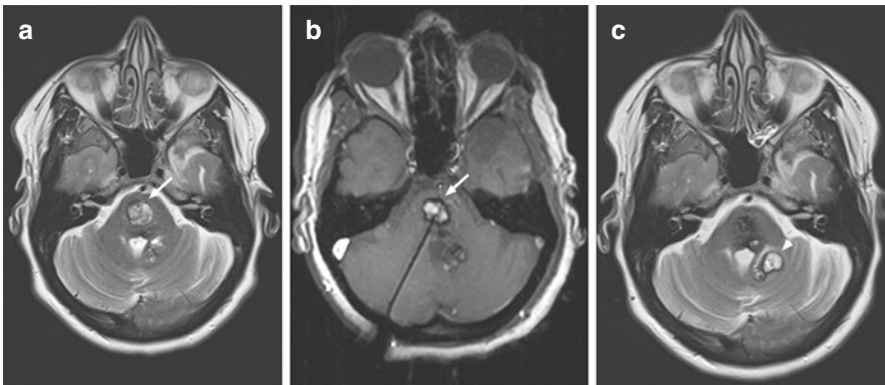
Case 1—LITT treatment of a pontine CM. (a) Preoperative axial T2-weighted MR imaging demonstrates a pontine cavernous malformation (arrow) with heterogenous hyper- and hypointense features. (b) Perioperative axial T1-weighted, contrast-enhanced MR image shows the right cerebellar approach for LITT treatment of the pontine lesion (arrow). (c) At 1 year after surgery, the axial T2-weighted MR image shows involution of the pontine lesion but formation of a new left cerebellar peduncle CM (arrowhead)
